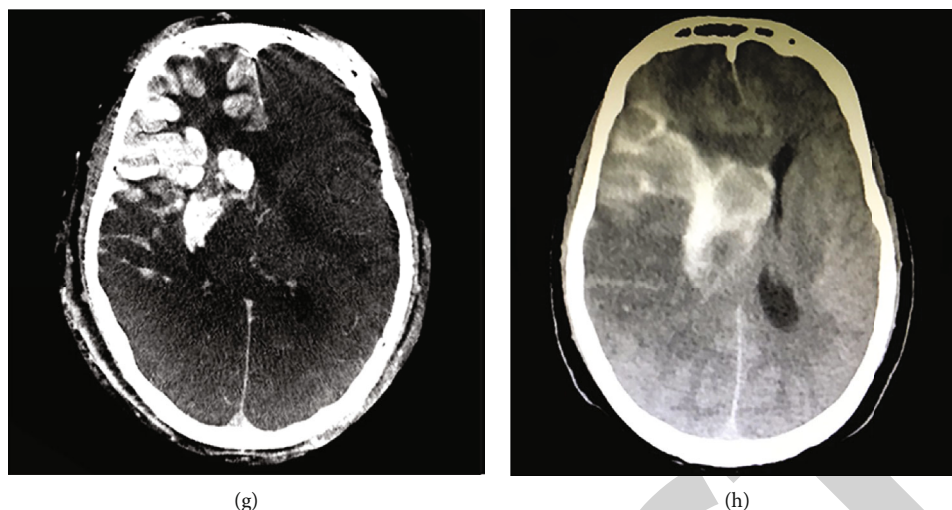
Images of sample patients. A 56-year-old man with acute occlusion of the left middle cerebral artery (a) received successful recanalization (b). Flat panel CT shows hyperdense lesion in the head of the left caudal nucleus (c), which resolved on noncontrast CT 24 hours after thrombectomy (d). A 67-year-old man with acute occlusion of the right internal carotid artery (e) received successful recanalization (f). Flat panel CT shows hyperdense lesion in the right basal ganglia and right middle cerebral artery territory (g), which persisted on noncontrast CT (h).
